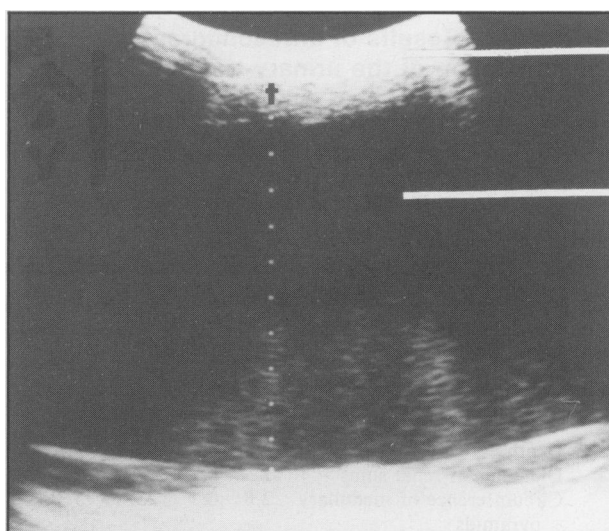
Ultrasonogram obtained from the linea alba of a ram with urine accumulation in the abdomen because of rupture of the urinary bladder. Top line = abdominal wall, second line = urine accumulation in the abdomen, + = cursor marks; dots = distance between cursor marks (10.8 cm).
